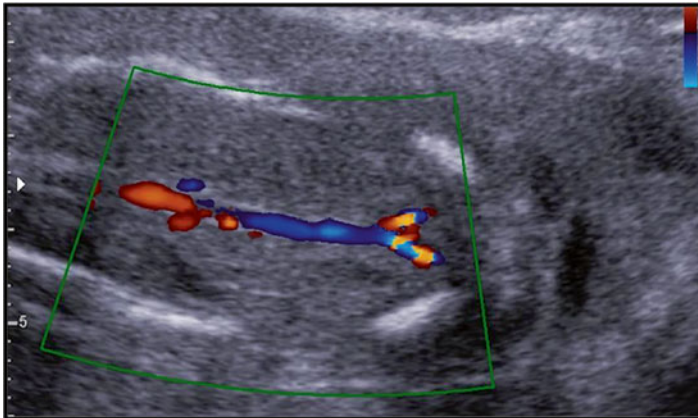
Bilateral renal agenesis:* Coronal ultrasound with color Doppler demonstrating the absence of both kidneys: both renal fossa are empty, and both renal arteries are absent
